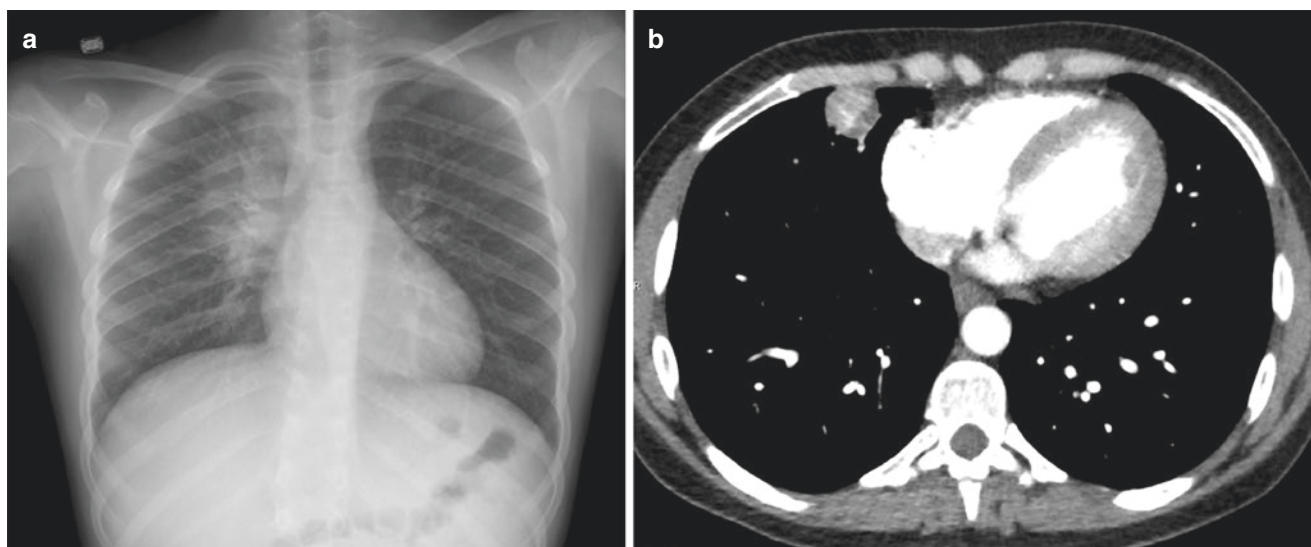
Imaging features of IMT. (a) Chest X-ray showing right upper lung collapse with a questionable underlying mass. (b) Chest CT scan from a different patient with a parenchyma IMT showing a solitary well-demarcated right upper lobe mass with somewhat irregular borders
